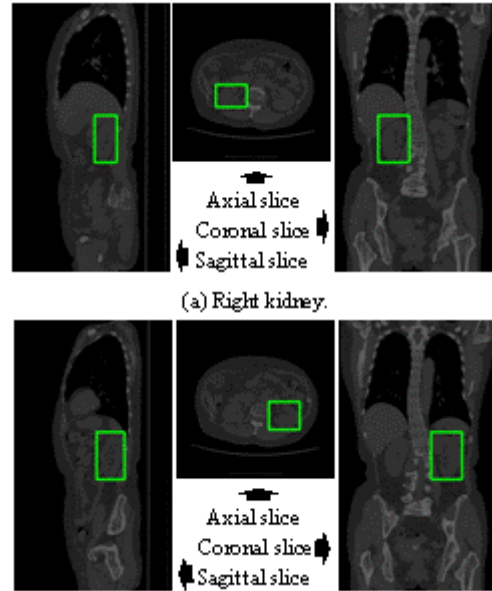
An example of kidney detection results. Three slices that pass through the detected center position of kidney in a CT image are shown. Green box indicates the detected kidney location (minimum bounding rectangle of kidney region).
